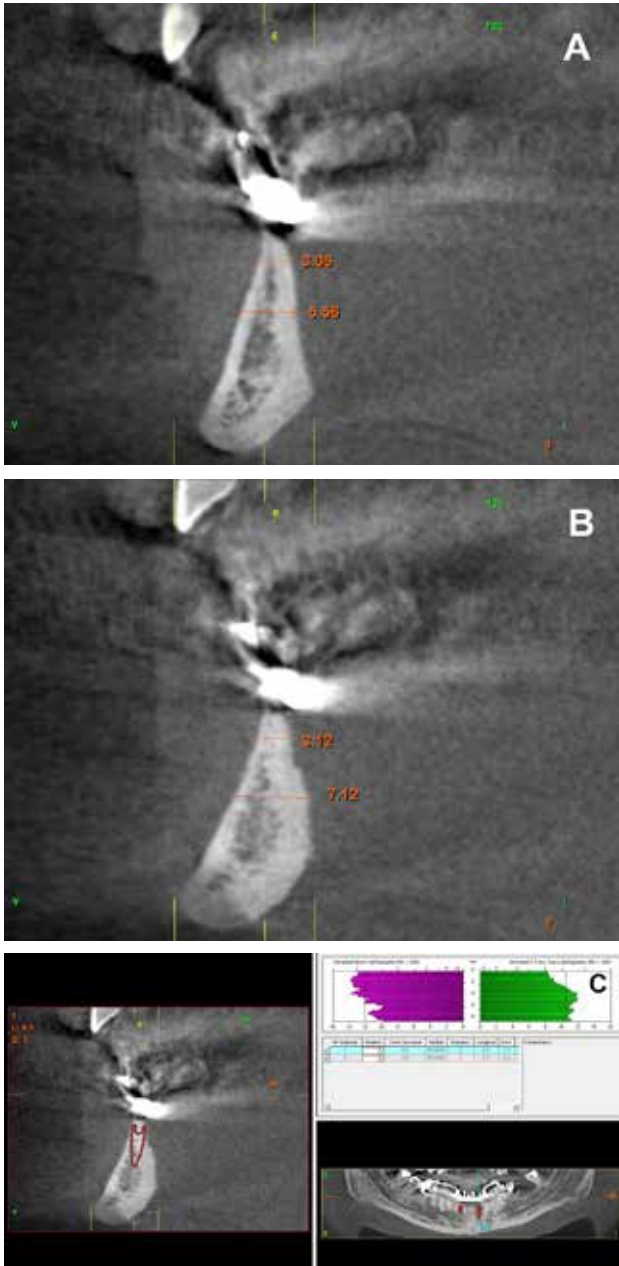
Dental CBCT planning images showing the extreme horizontal resorption of the antero-inferior sector in the incisor area; (A) area corresponding to tooth 42 (B) area corresponding to tooth 32 (C) Planning of the expander implant in the CT cut.
